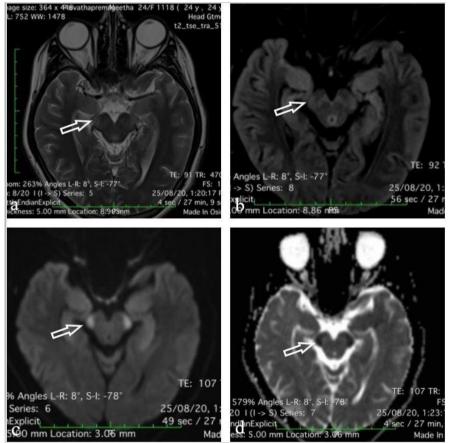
MRI axial sections of the same patient showing T2W image (a), FLAIR (b), DWI (c) and corresponding ADC mapping (d) reveals symmetrical T2 /FLAIR hyperintensity with diffusion restriction (open arrows) in bilateral cerebral peduncle of midbrain.
